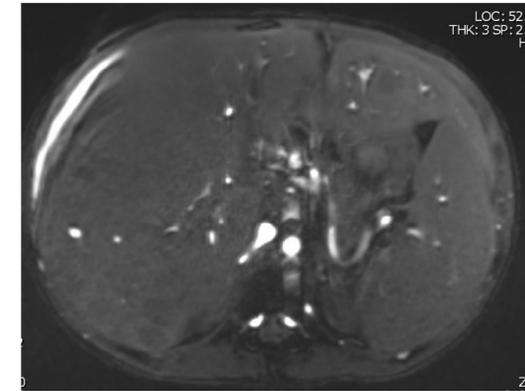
MRI Abdomen MRCP with and without contrast – Initial Evaluation (Day 28)
